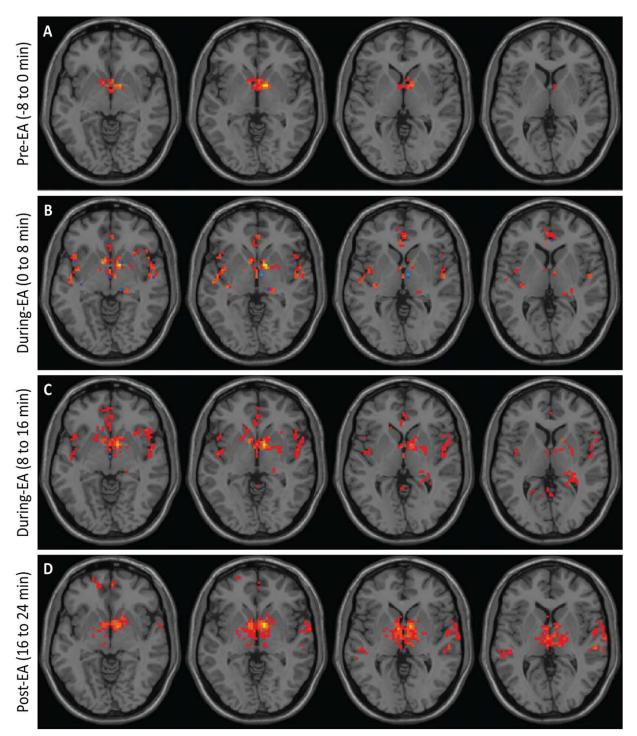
Electroacupuncture (EA) stimulation increases hypothalamic functional connectivity in humans. Brains from normal subjects were monitored using functional magnetic resonance imaging before, during, and after EA. Functional connectivity increased within the hypothalamus and between the hypothalamus and adjacent brain regions with progression of treatment (n = 6).
